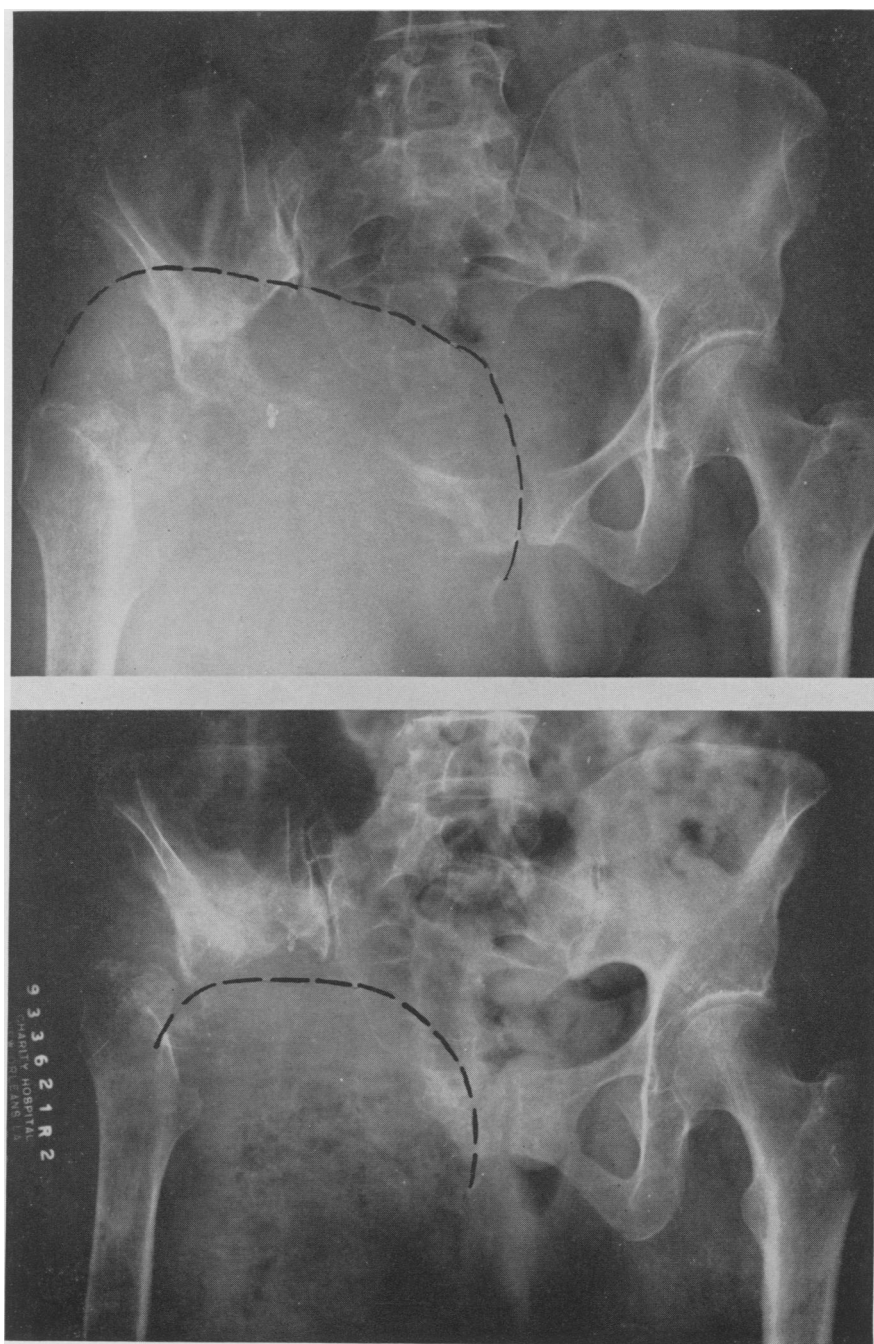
Roentgenograms in Case 3, (a) (upper) before, and (b) (lower) after perfusion with nitrogen mustard.
